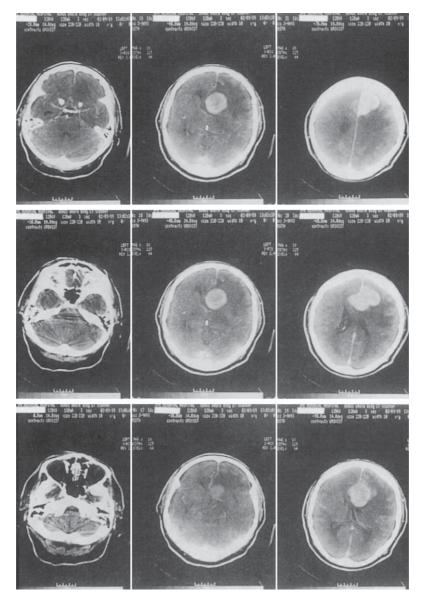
CT scan of a large tumor located in the cerebrum. Note that slices above and below the lesion provide an evaluation of the structures adjacent to the tumor.
